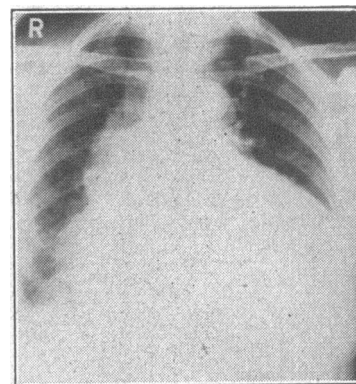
Chest x-ray film of patient shown in Fig. 8; great cardiac enlargement.
